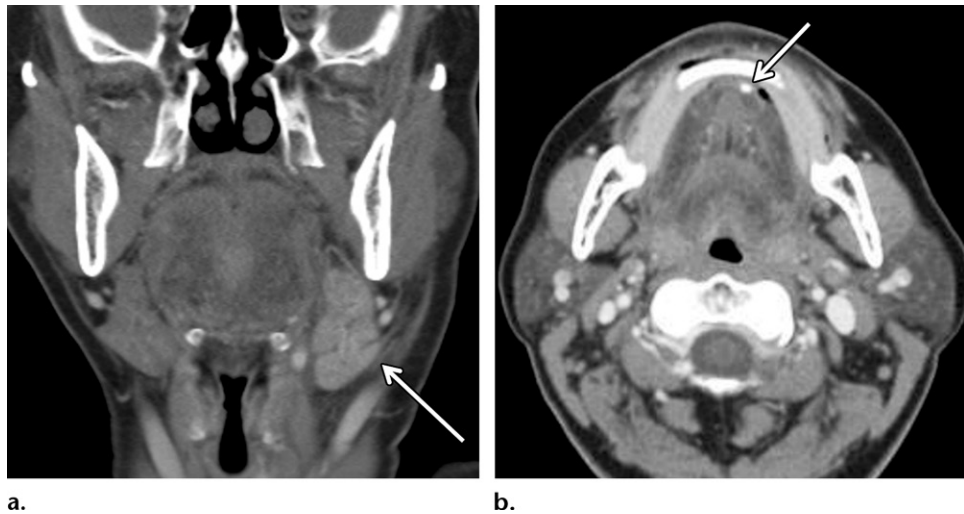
Sialadenitis in a 50-year-old woman with left neck swelling and severe pain after eating lunch. (a) Coronal CT image shows enlargement and enhancement of the left submandibular gland, with mild surrounding edema (arrow). (b) Axial CT image shows a stone at the submandibular duct orifice (arrow) in the floor of the mouth.
